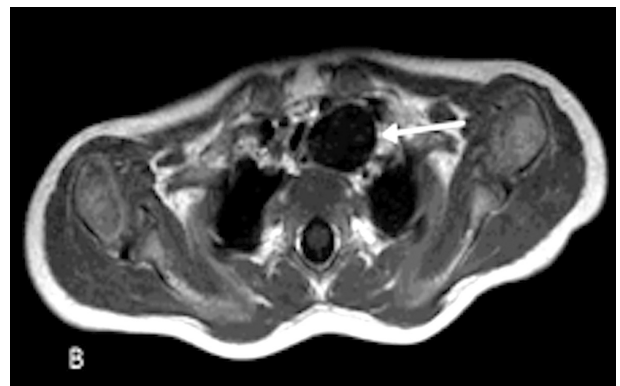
(A) CT shows cystic formation localized in the upper mediastinum causing right dislocation of esophagus. (B) On MRI the cyst appears hypointense on T1W sequence
